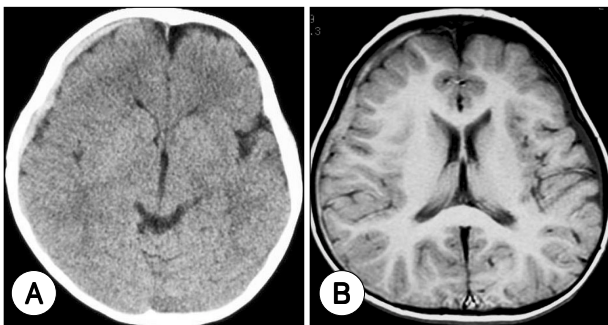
A : Initial computed tomography showing minimal subdural hematoma on right frontotemporal area. B : Initial T1-weighted magnetic resonance imaging showing minimal subdural hematoma on right frontotemporal area.
